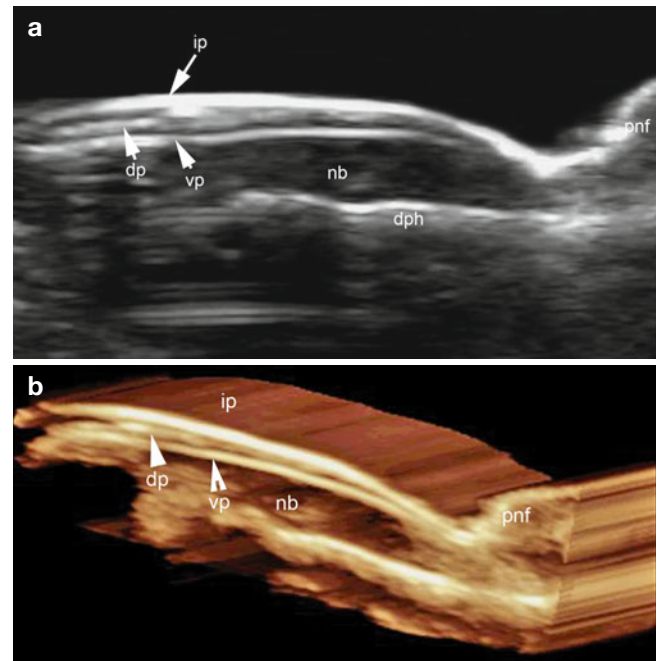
(a, b) Acrylic nail implant. (a) Grey scale ultrasound images (longitudinal view); and (b) 3D reconstruction demonstrate a trilaminar hyperechoic pattern of the plates. The most superficial layer corresponds to the acrylic implant (ip, arrow). Abbreviations: vp ventral plate, dp dorsal plate, nb nail bed, pnf proximal nail fold, dph distal phalanx, ip acrylic implant
